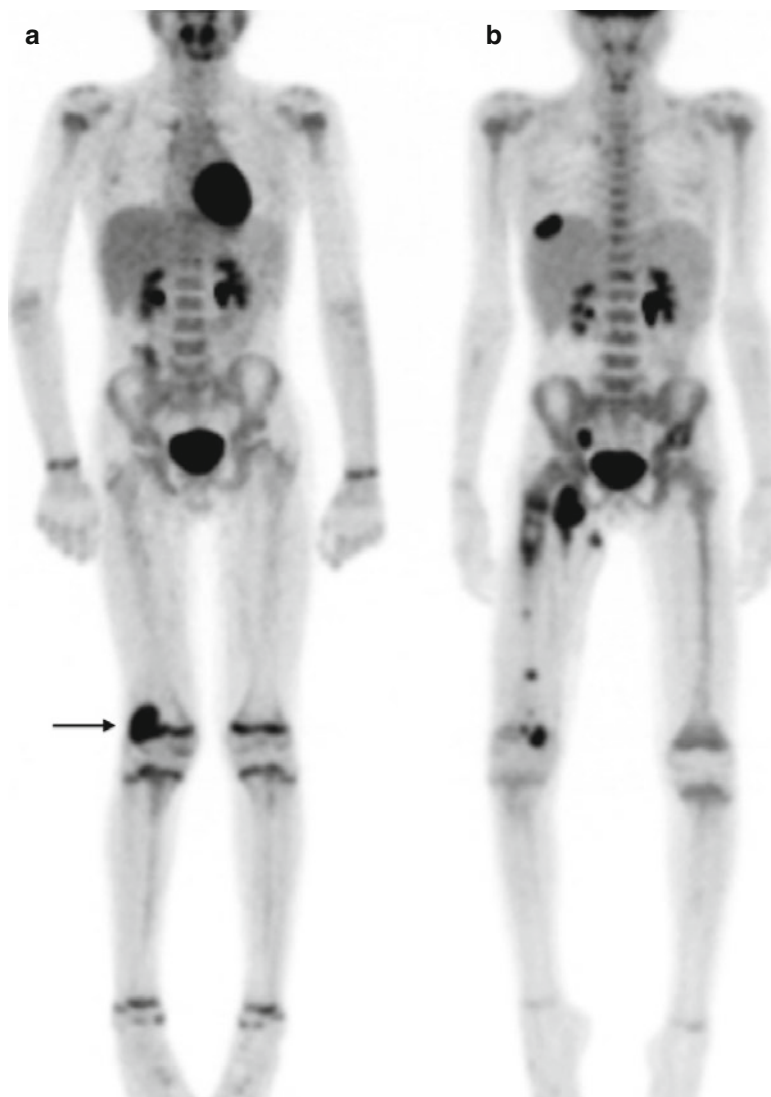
Undifferentiated high-grade large cell sarcoma. An 11-year-old male presented with a mass in the right popliteal fossa. Biopsy showed undifferentiated sarcoma. (a) MIP image. Staging with CT and ^{18}F -FDG PET/CT showed a localized mass (*arrow*) with no evidence of metastases. A sentinel lymph node biopsy of a femoral lymph node was negative. The patient underwent chemotherapy and showed an initial response on ^{18}F -FDG PET and CT. After the third cycle of chemotherapy, the patient developed a mass in the right femoral
